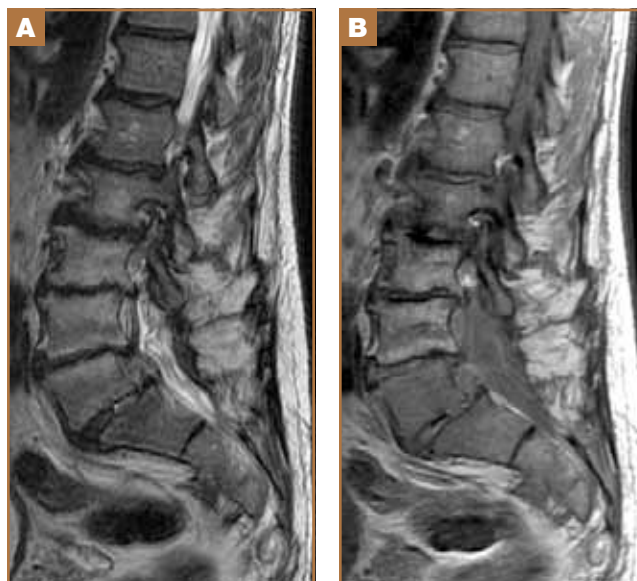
Sagittal T₂-weighted (A) and T₁-weighted (B) magnetic resonance imaging of lumbar spine shows increased signal within L5–S1 disk space. This study was performed at initial crisis and presentation. In this clinical setting, these findings suggest discitis.
